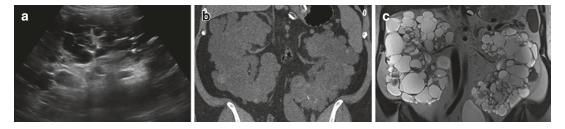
Enlarged kidneys with numerous cysts on ultrasound (a), non-contrast coronal CT (b), and T2 weighted image CT (c). Some cysts contain hemorrhagic
